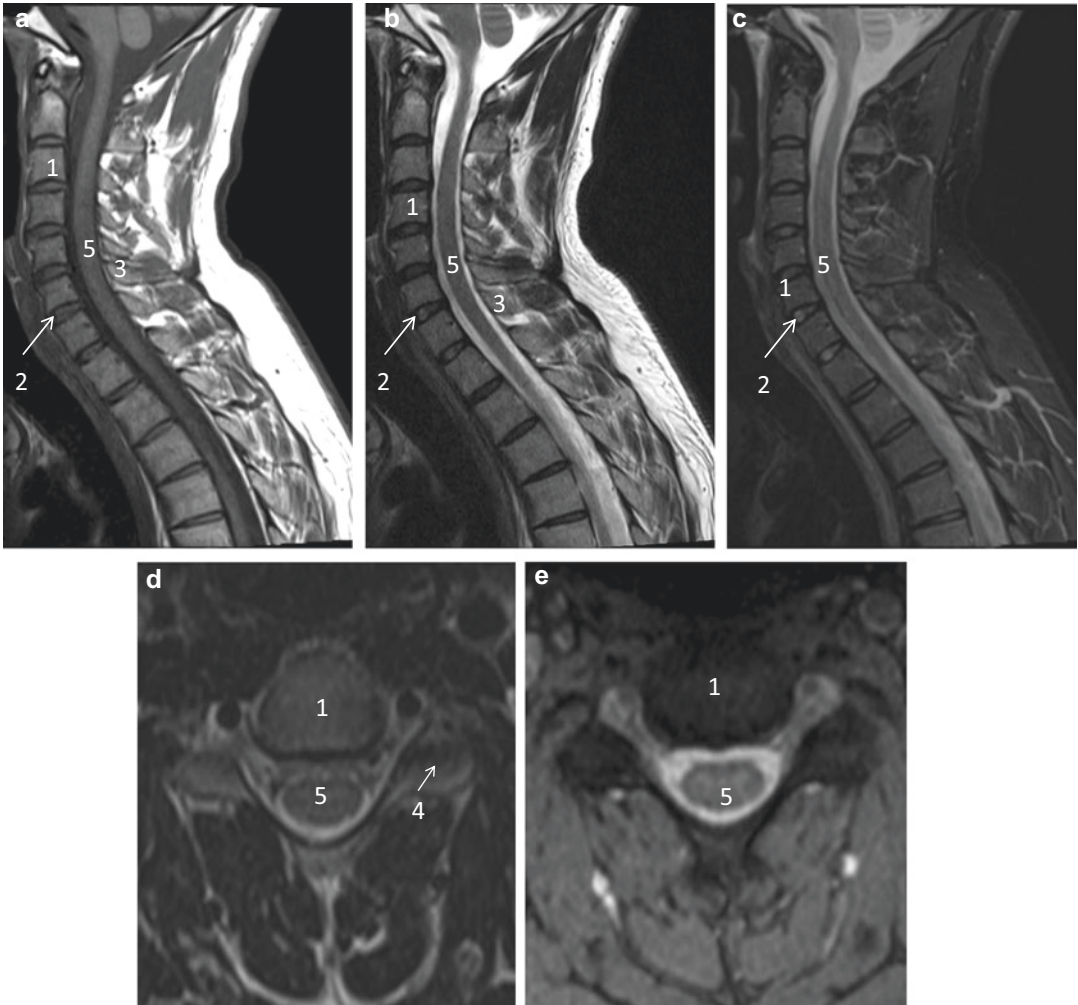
Representative MR images of cervical spine. (a) Sagittal T1, (b) Sagittal T2, (c) Sagittal STIR, (d) Axial T2, and (e) Axial T2* sequences. (1) Vertebral
